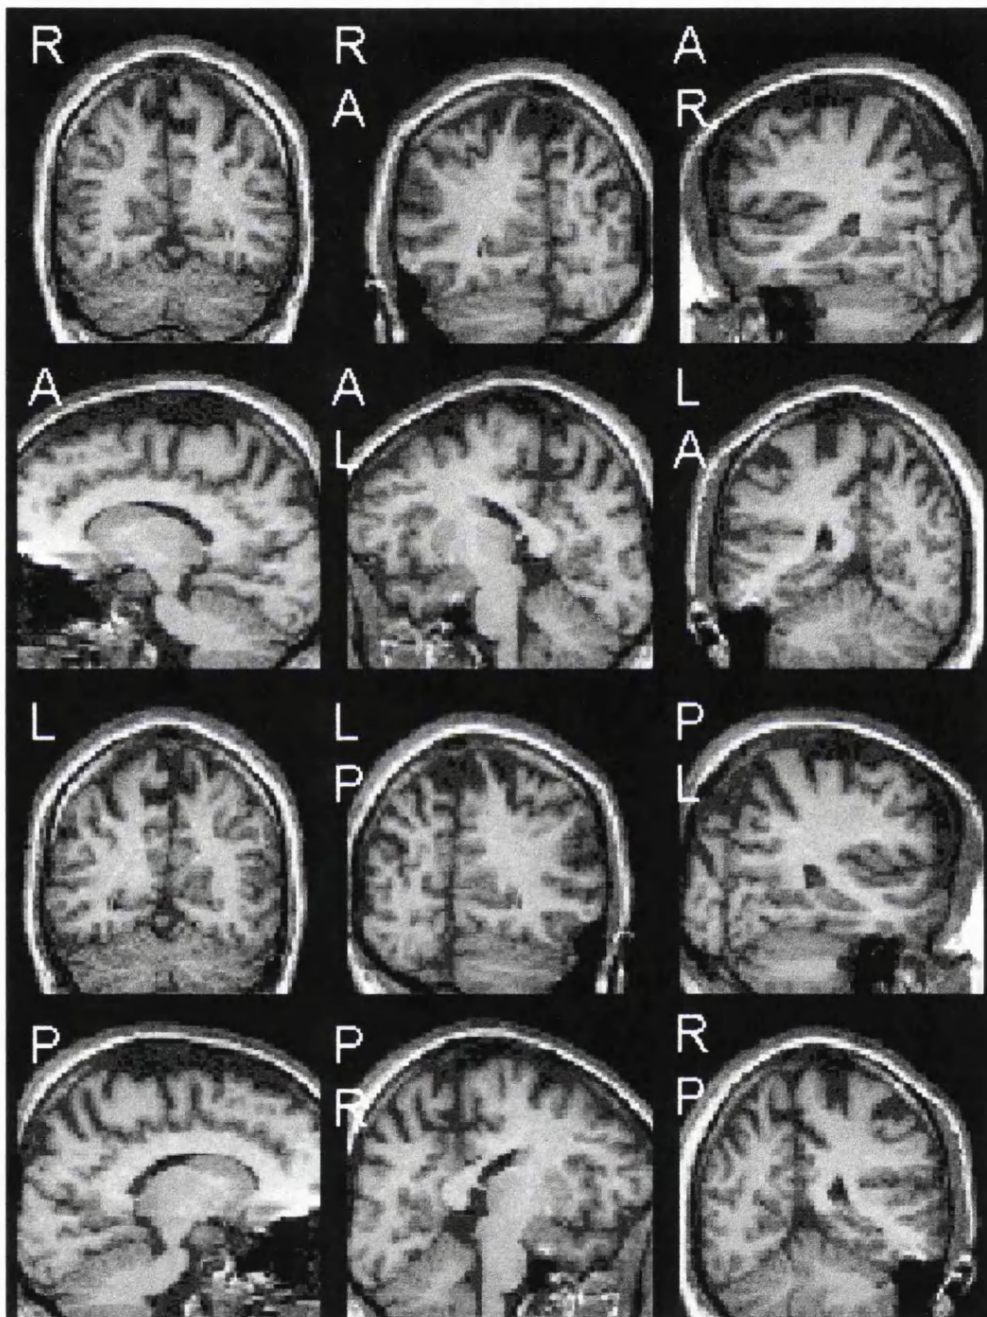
REFORMATTED 3D IRSPGR images (predominantly T1-weighted); the 3D data set has been rotated 360° in steps of 30° around the vertical axis. The cortex around the right calcarine sulcus is thicker than the cortex around the left calcarine sulcus but no clear-cut abnormality is visible. R=right, L=left, A=anterior, P=posterior
